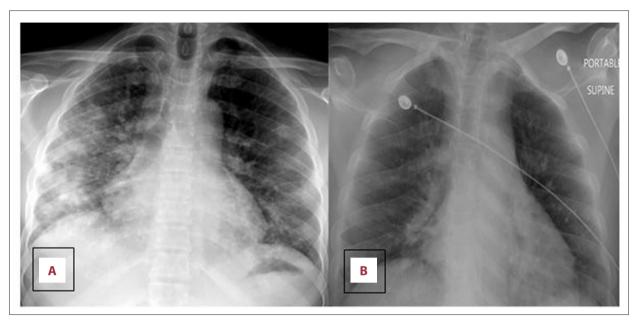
(A) Chest radiograph shows patchy areas of consolidation in the left lower lobe. (B) Chest radiograph shows complete resolution of the pulmonary infiltrates at the 1-month follow-up visit.
